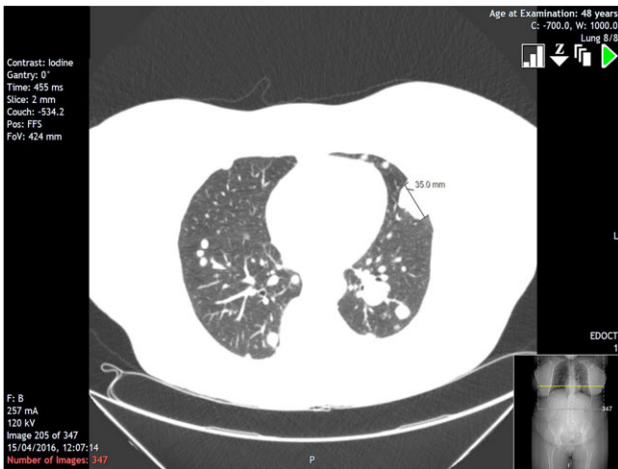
Section from CT scan showing largest individual lung lesion in the lingula measuring 3.5 cm.
